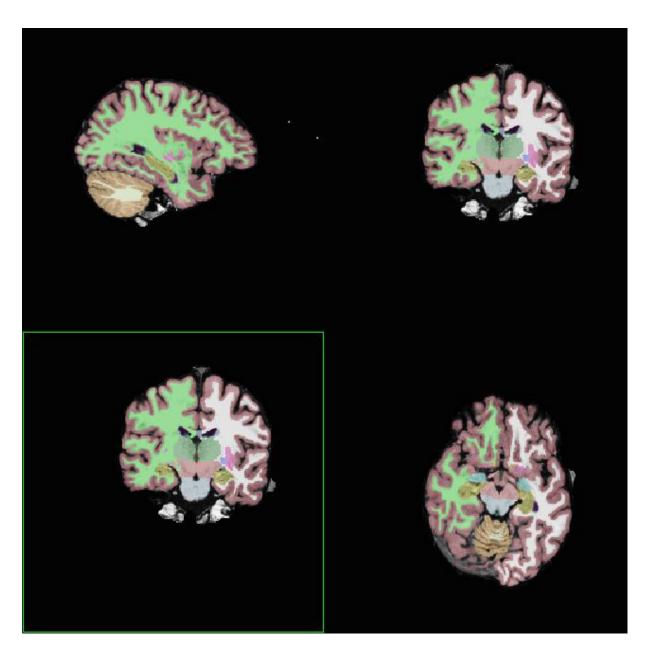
Right hippocampus (image obtained from a subject MRI).
